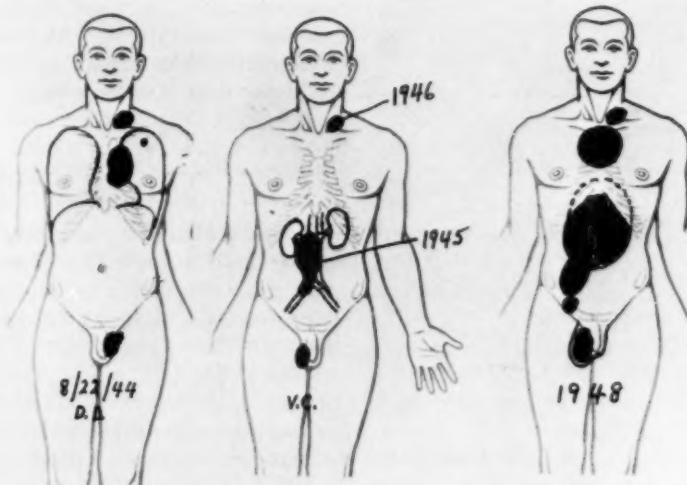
Three seminoma patients irradiated with 1,000-kv x-rays and free of disease from eight to twelve years later.
